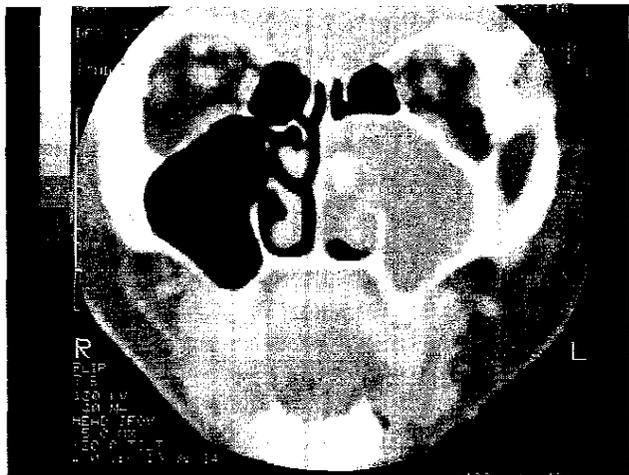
A coronal CT showing heterogenous opacities of the left maxillary and nasal cavities, with the shadow of the dental root in the nose.
